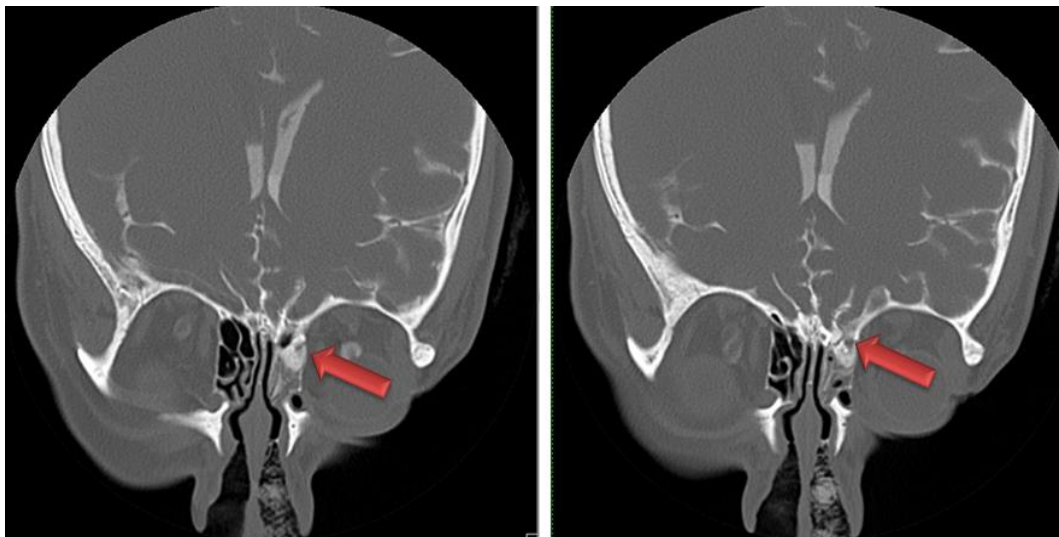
CT cisternography: it reveals the contrast agent travelling from the subdural area to the right nasal fossa (red arrow)
